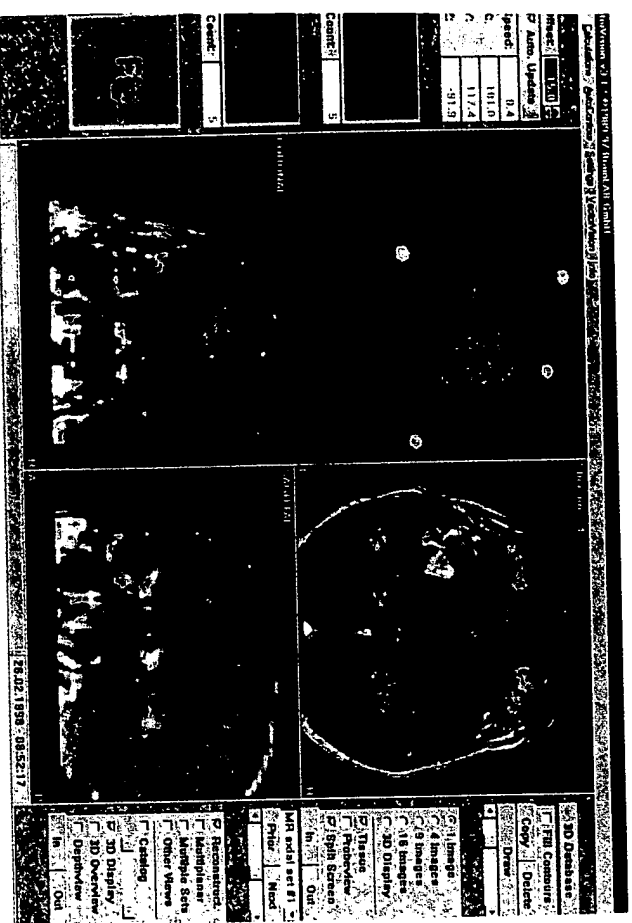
Resection area and installation area was carefully planned using three-dimensional reconstructions of CT/MRI scans. This procedure provides the surgeon with more safety during the surgical procedure. The VPC can be administered with higher accuracy.
